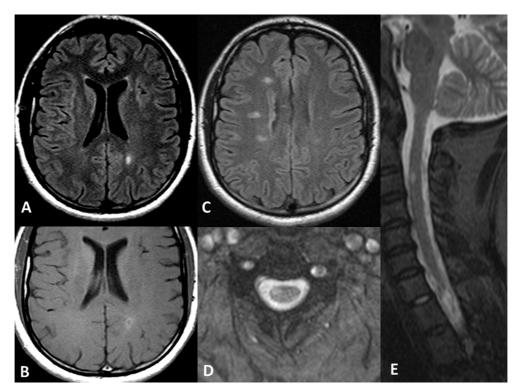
A focal subcortical hyperintense FLAIR lesion (A) with contrast enhancement (B) is observed in conjunction with other periventricular and pericalosal bright lesions (C), similar to Dawson's fingers described for MS disease. Cervical lesions follow the same pattern, eccentrically located in the T2* axial plane (D) and extending for one vertebral body dimension on the sagittal STIR cervical image (E).
